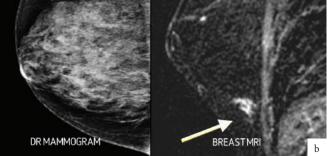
Two cases of cancer (a and b) obscured in dense breasts that were visible (arrows) on MR imaging.
